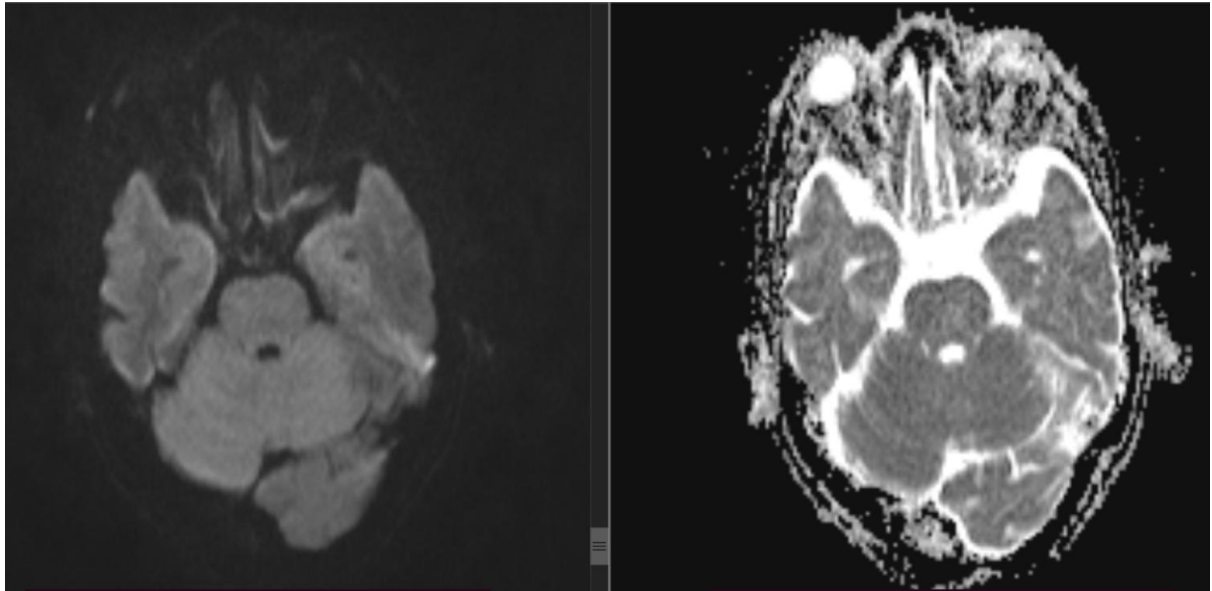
No diffusion restriction on DWI
